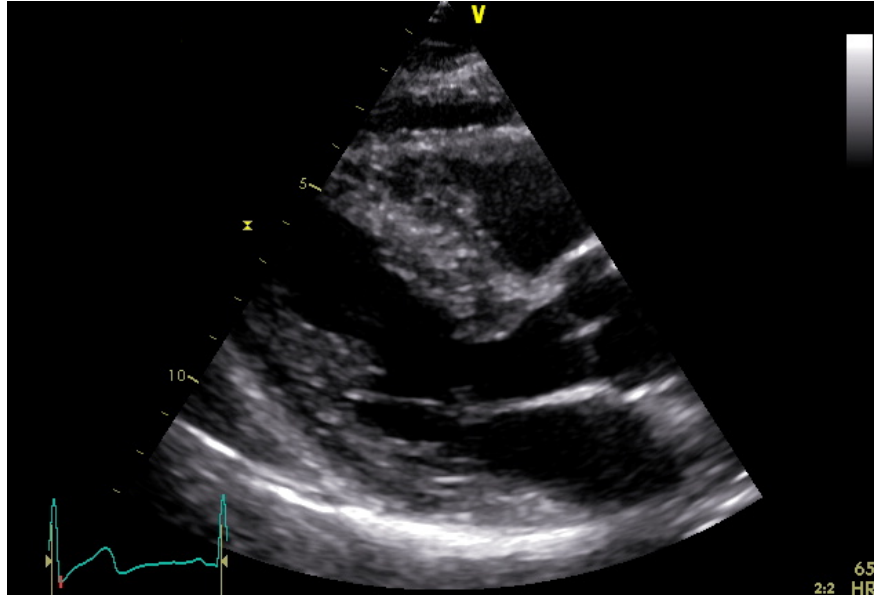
Longitudinal parasternal end - diastolic plane: Asymmetric septal hypertrophy (interventricular septum thickness 15 mm).
